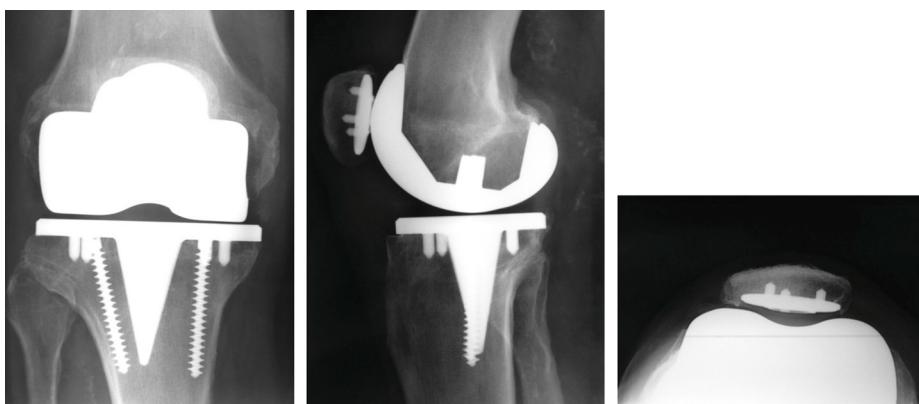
Radiograph of fixed-bearing implant after 12 years showing joint space narrowing due to polyethylene wear.
